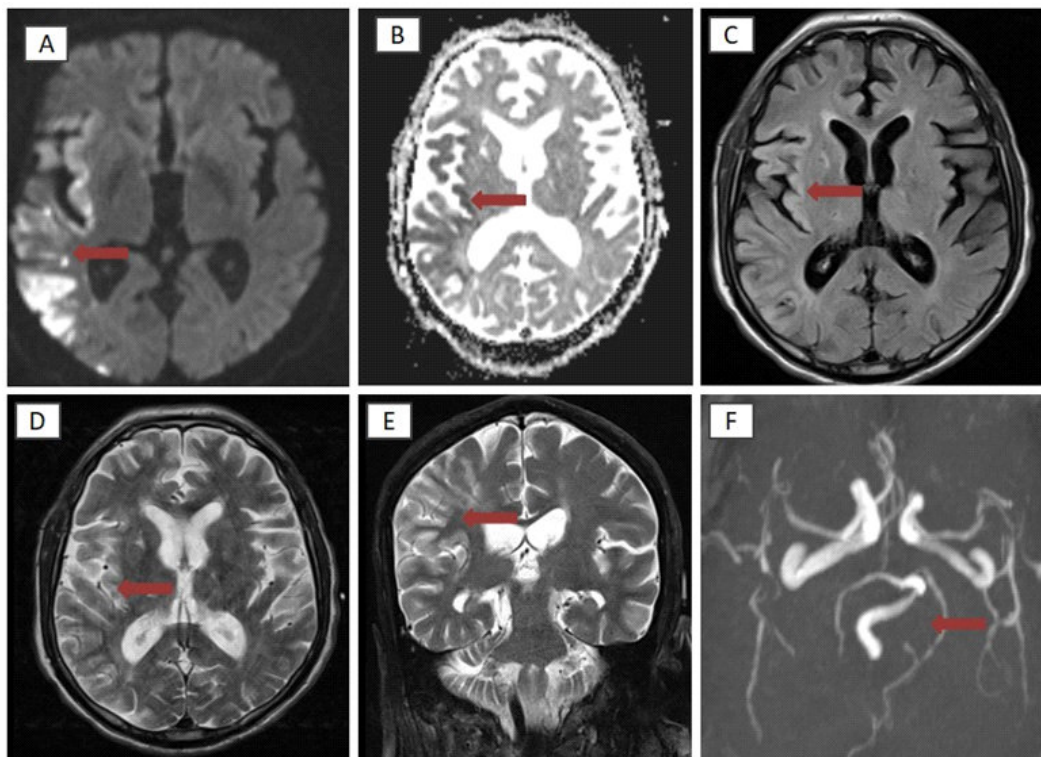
MRI brain axial section showed diffusion restriction in right temporo parietal region (A) with ADC reversal (B) as marked with red arrow and Fluid-Attenuated Inversion Recovery / T2 weighted imaging showing corresponding hyperintensity in temporo parietal cortex (C, D) and T2 weighted coronal section showing hyper intensity in temporo parietal cortex (E) with no involvement of thalamus or hypothalamus. MR angiogram showed non-visualization of the left vertebral artery (F).
